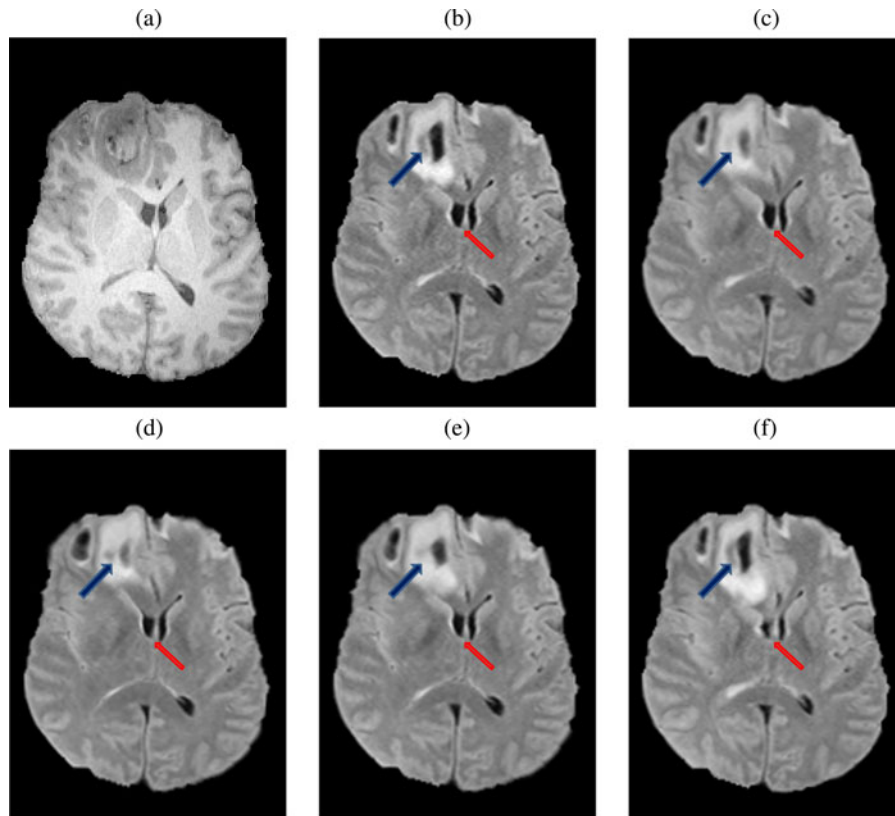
Registration comparison: deforming FLAIR to match T_1 . The viscous model based on either MI or the BD is compared with BRAINSFit [39] and ANTs [41]. (a) T_1 (static). (b) T_2 (moving). (c) by BRAINSFit. (d) by MI. (e) by BD. (f) by ANTs.
